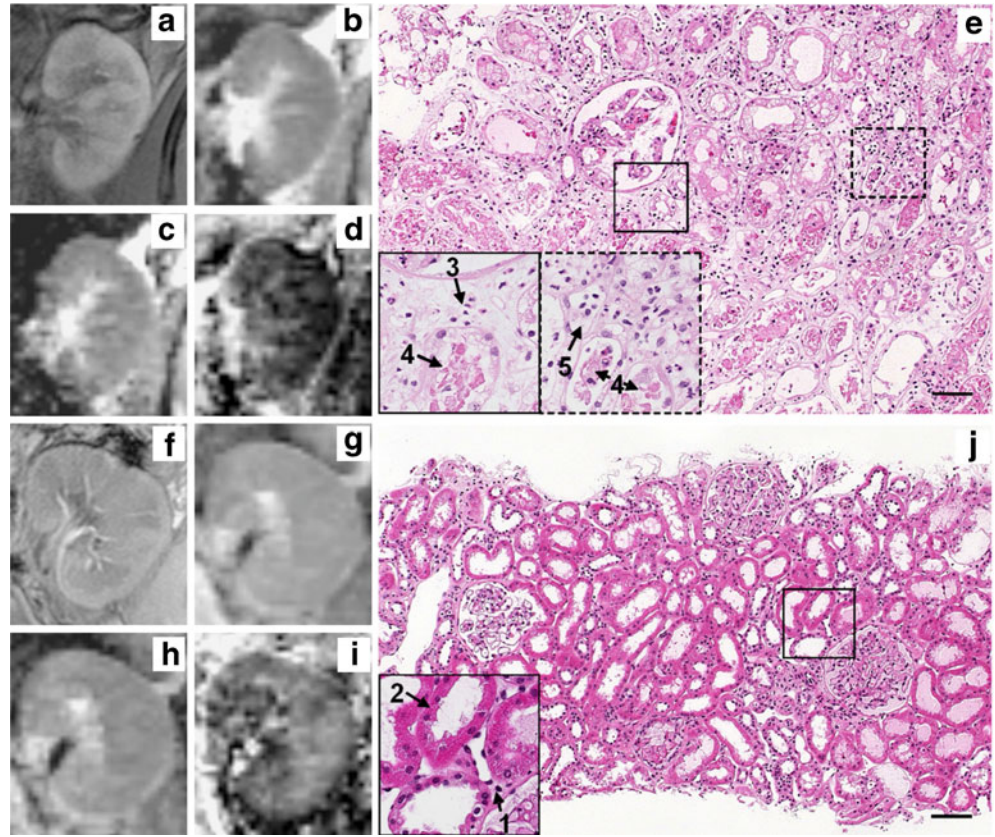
Morphological MR images and parameter maps from DW-MRI of one subject (S2) presenting first with an inadequately functioning allograft (right side) and a well-functioning allograft (left side). T1-weighted FLASH-MRI (a), maps for ADC_T (b), ADC_D (c) and F_P (d). The signal intensity was lower (darker shade) on all diffusion maps of the first implanted (smaller) kidney
